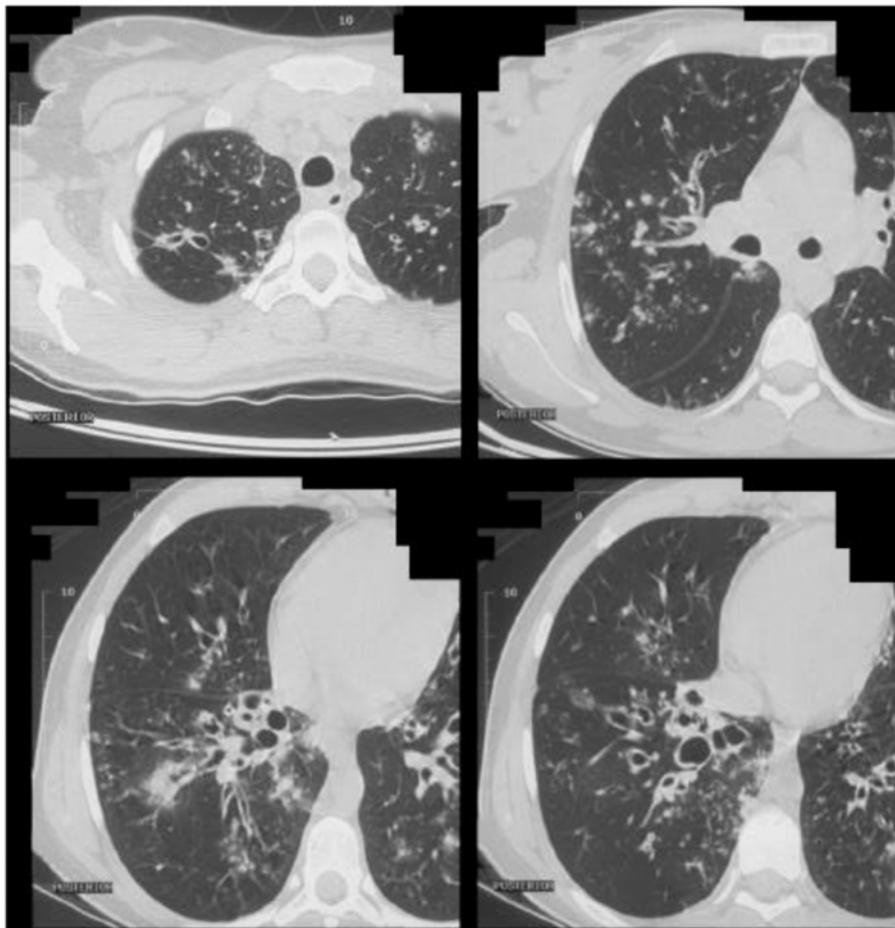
High resolution CT scan of chest.
